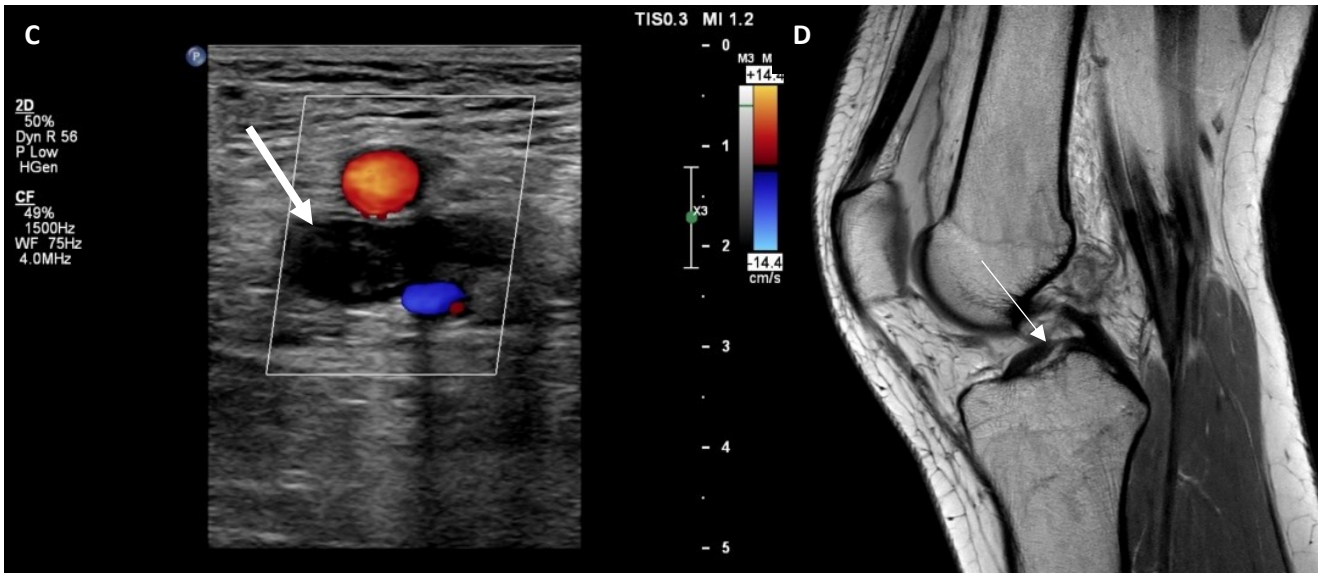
C - Ultrasound image of deep vein thrombosis –dilated incompressible lumen of the vein filled with the hypochoic thrombus (white arrow), surrounding arteries with visualised flow
